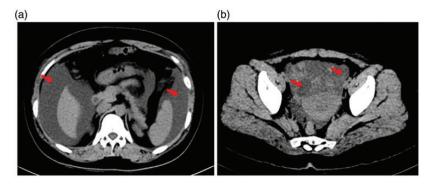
Abdominal computed tomographic examination. (a) A large amount of ascites can be seen (red arrows). (b) Irregular abnormal density shadows (red arrows) above the uterus in the pelvic cavity can be seen.
